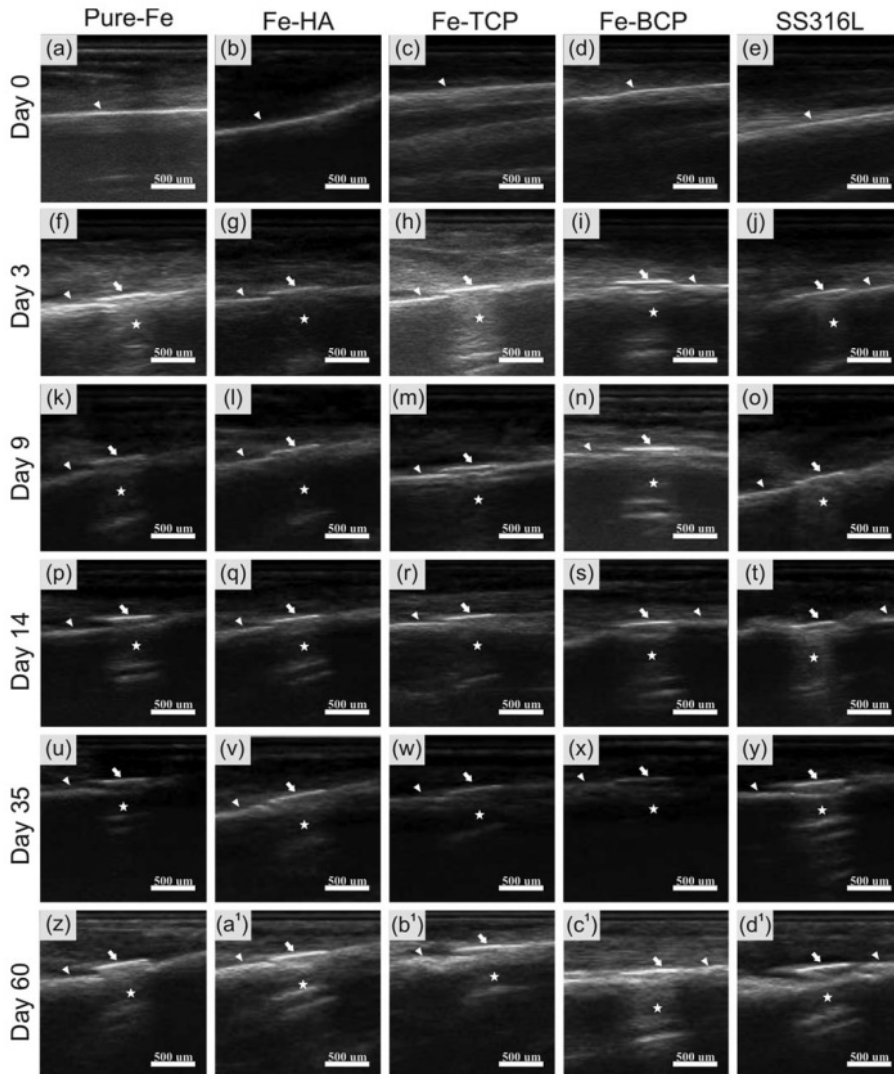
Sonogram of the implants at different days postimplantation. Note: “arrow” = implant, “arrow head” = bone, “star” = comet-tail artefact at the bottom of implant in the bone marrow.
